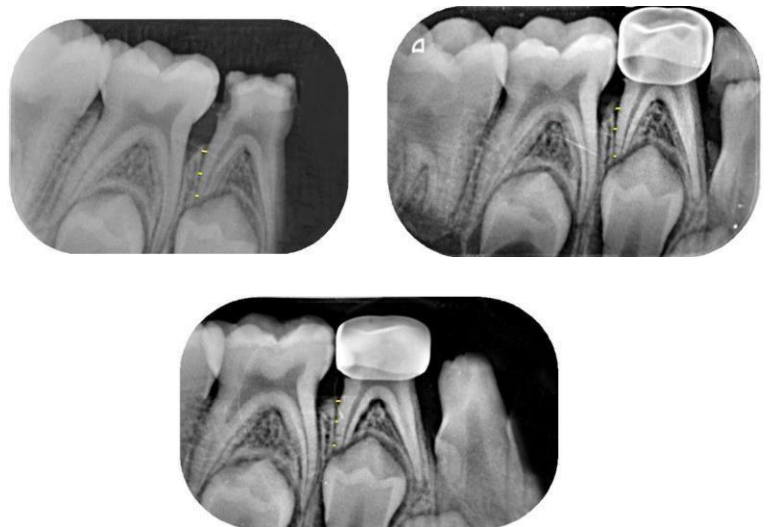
Intraoral periapical radiographs showing radiographic changes of PDL width in primary molars following placement of hall technique crown
